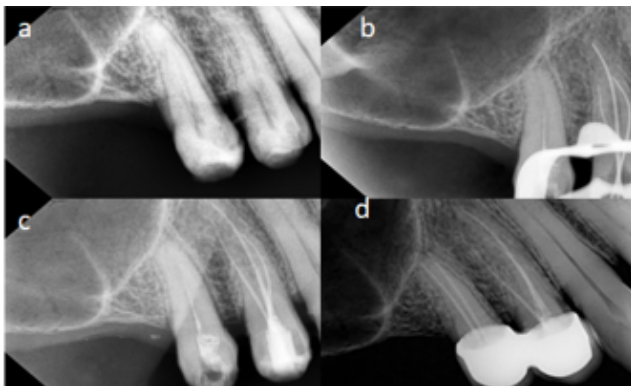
a: Pre op radiograph, b: Canals 3roots, c: Obturation, d: 1 Year follow up
